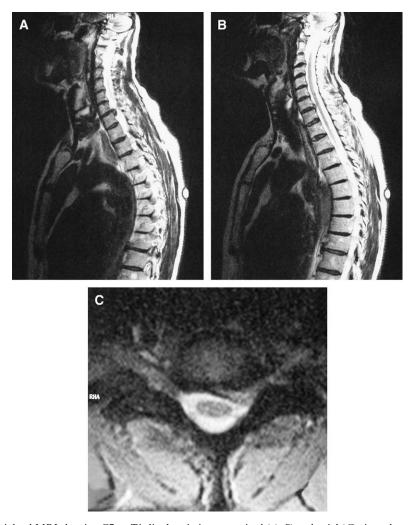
T2-weighted MRI showing C7-to-T1 disc herniation on sagittal (A, B) and axial (C) views demonstrates lateral disc herniation compressing the left C7 root.
